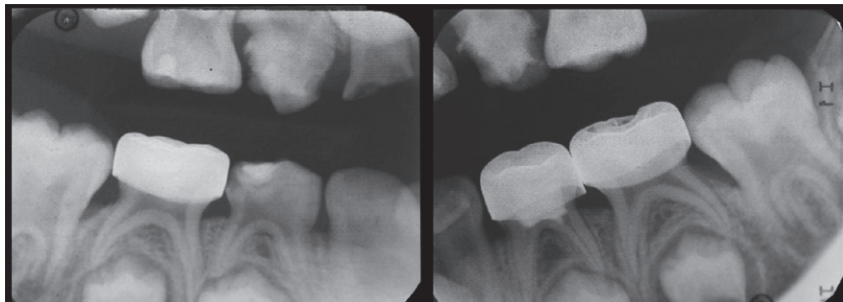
Bitewing radiographs taken at the time of the second general anaesthesia when the patient was six years and ten-months-of-age.
